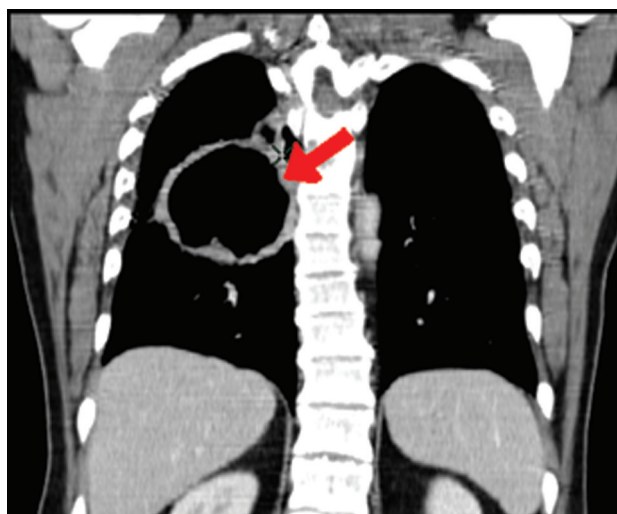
Resonconstructed coronal slice from CT chest/abdo/pelvis showing large pleural based abscess arising from T4-5 discitis (arrows)
